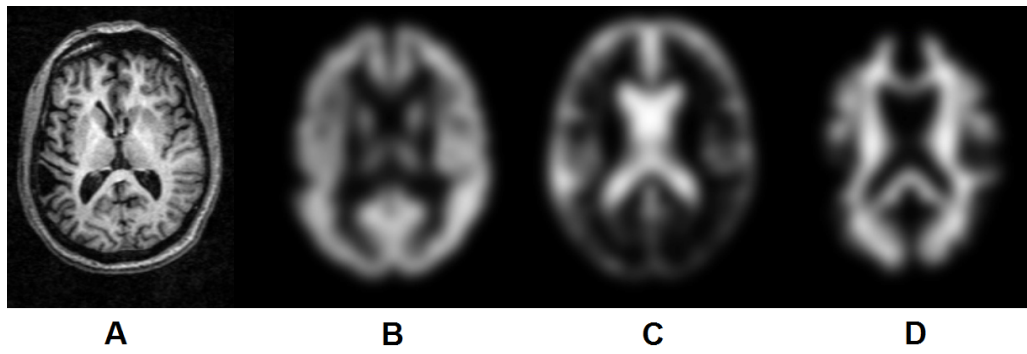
Example MRI scan (A) and its grey matter (B), white matter (C) and CSF (D) TPMs with FWHM smoothing applied.
